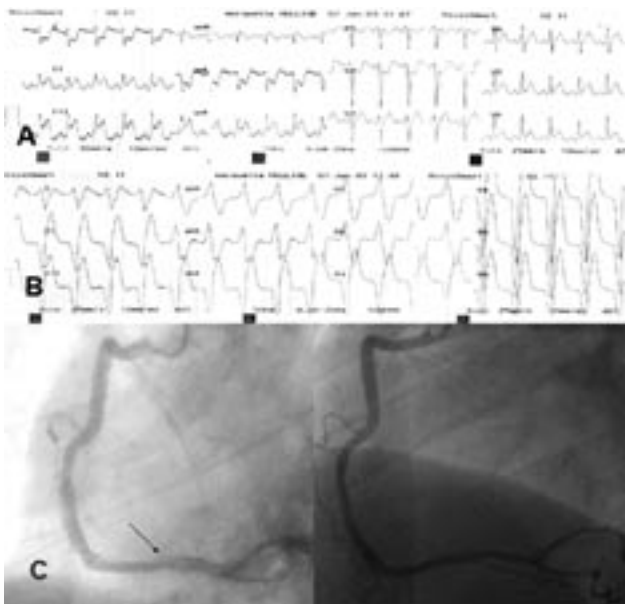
A: ST segment changes at the onset of angina during stress echocardiographic study. B: Idioventricular rhythm when angina began to relieve. C: Minor dissection of the distal part of the right coronary artery (arrow, left panel). Two days later complete restoration of the dissected right coronary artery wall (C, right panel).
